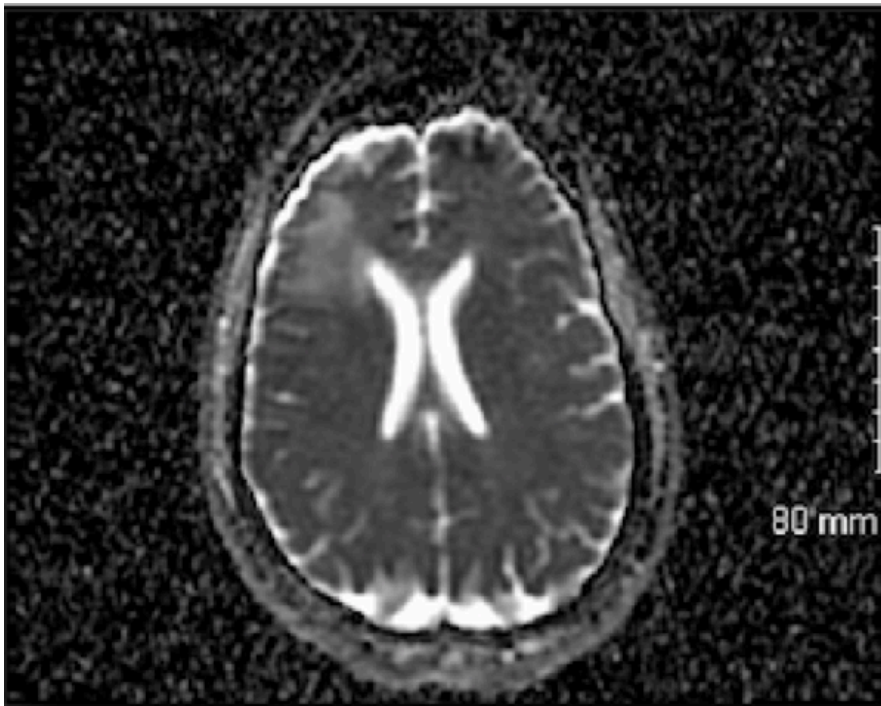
Postoperative MRI showing stable enhancement in the right frontal lobe.
